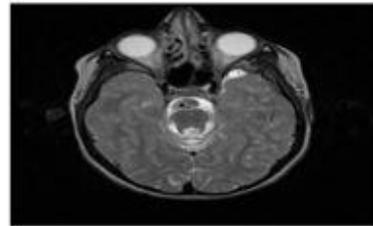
Joubert's syndrome. T2 weighted 3 Tesla MRI demonstrating Molar tooth appearance of the midbrain.
